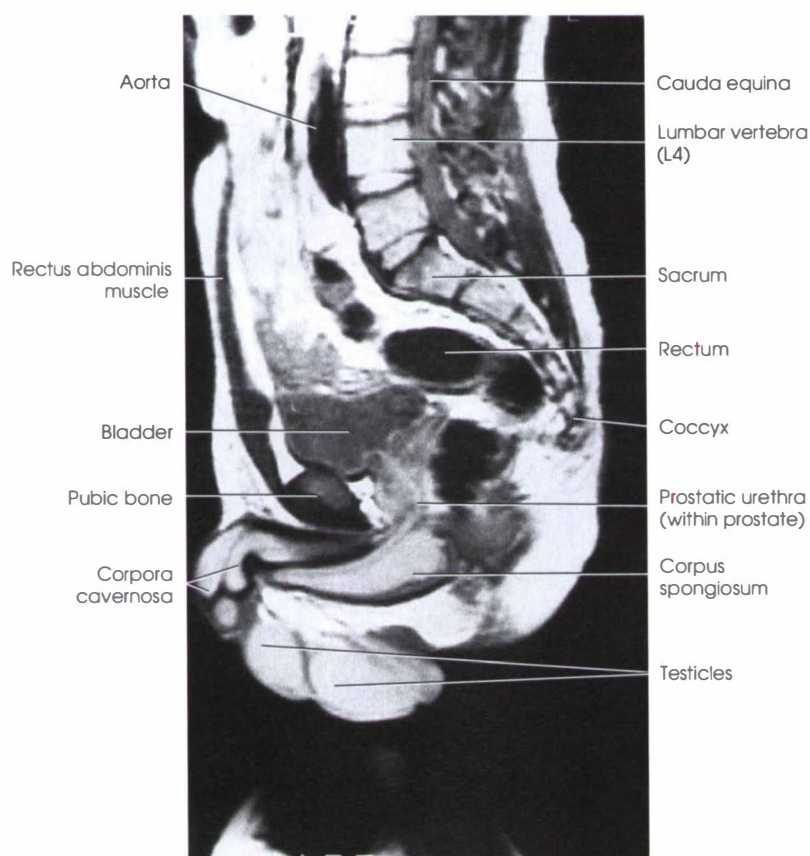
MRI of the abdominopelvic region at the midsagittal plane.
